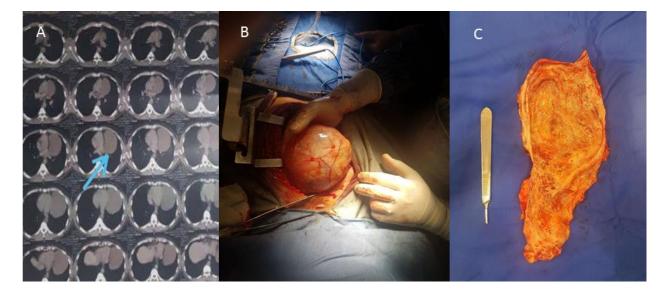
A: In the second case, a CT scan showed a large intrapericardial cyst attached to the pulmonary trunk (cystic mass at the left side of the heart: blue arrow); B: View of the second case after operation; C: View of the cyst of the second case after the operation
